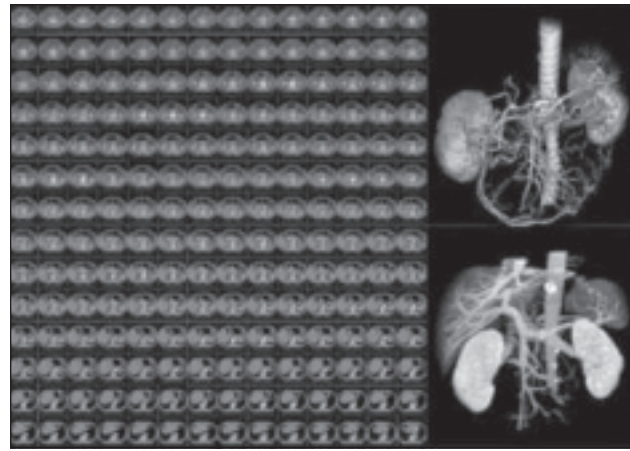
Rendering is the process by which a computer system takes a stack of slice images (left) generated by a volumetric acquisition modality, such as CT or MR, and converts them to a 3D volume-rendered representation (top right) using various look-up tables to convert source data values to colors and transparency or to a maximum intensity projection (bottom right) by projecting through the volumetric stack of slices in a given direction and recording only the brightest pixel encountered along each ray. (AquariusNET Client software image courtesy of TeraRecon, Inc.)
